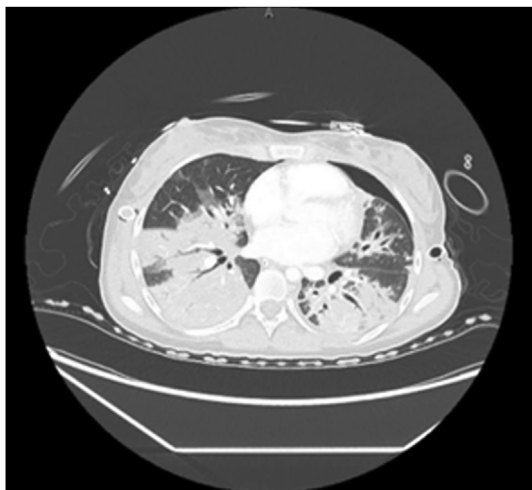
Coronal view of CT chest revealing multifocal bilateral infiltrates more on the right side with subpleural sparing, suggestive of vaping use.
